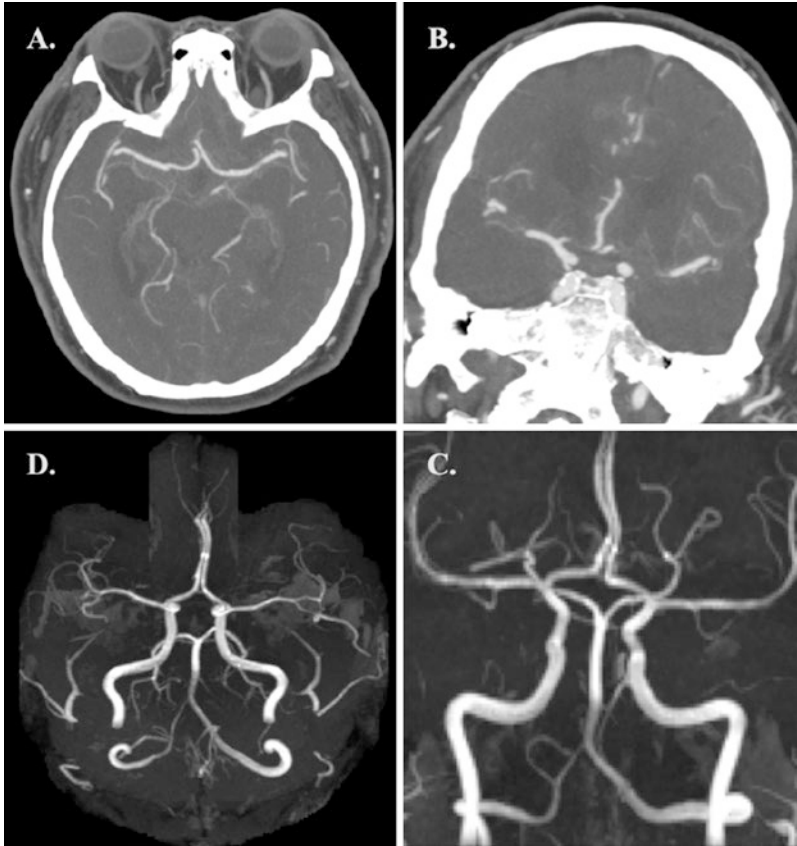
(a, b) Axial and coronal CTA MIP images demonstrating normal intracranial vasculature. (c, d) Coronal and axial 3D-TOF-MRA MIP images demonstrating normal intracranial vasculature
